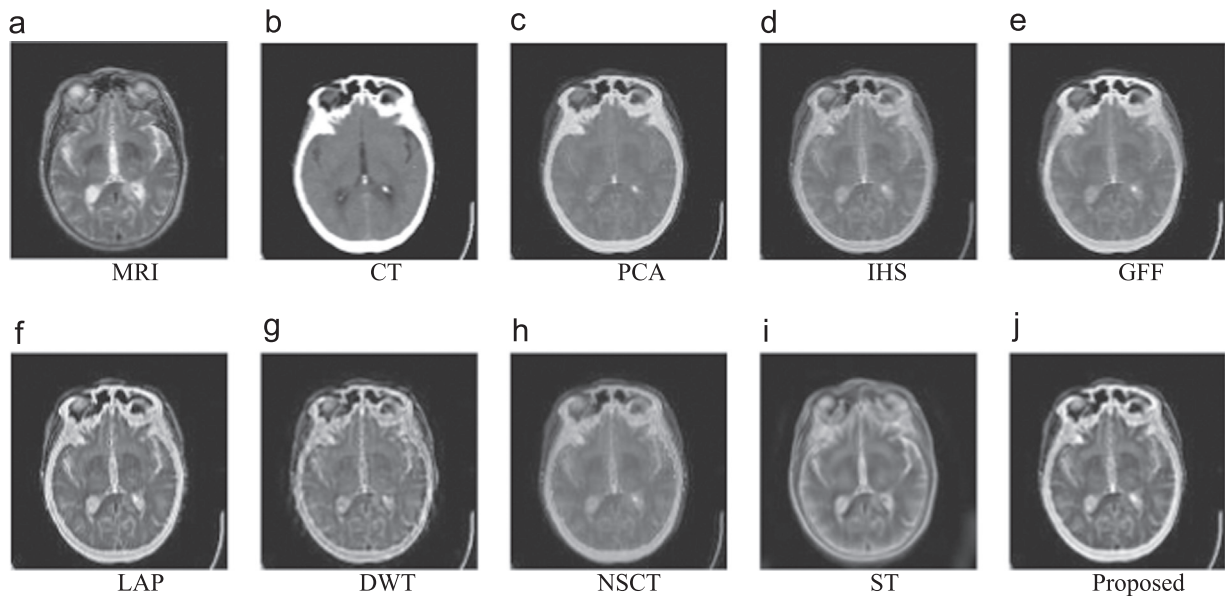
Example 1: Performance comparison of different methods on MRI-CT fusion.
